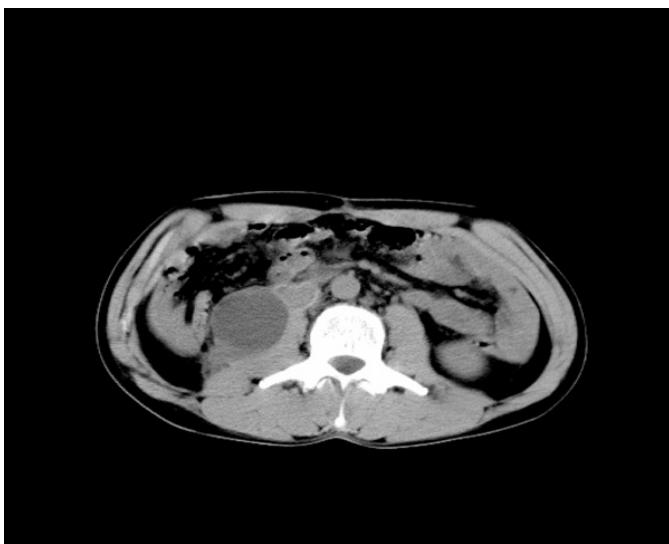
Abdominal computed tomography and graft and collection near the graft.
